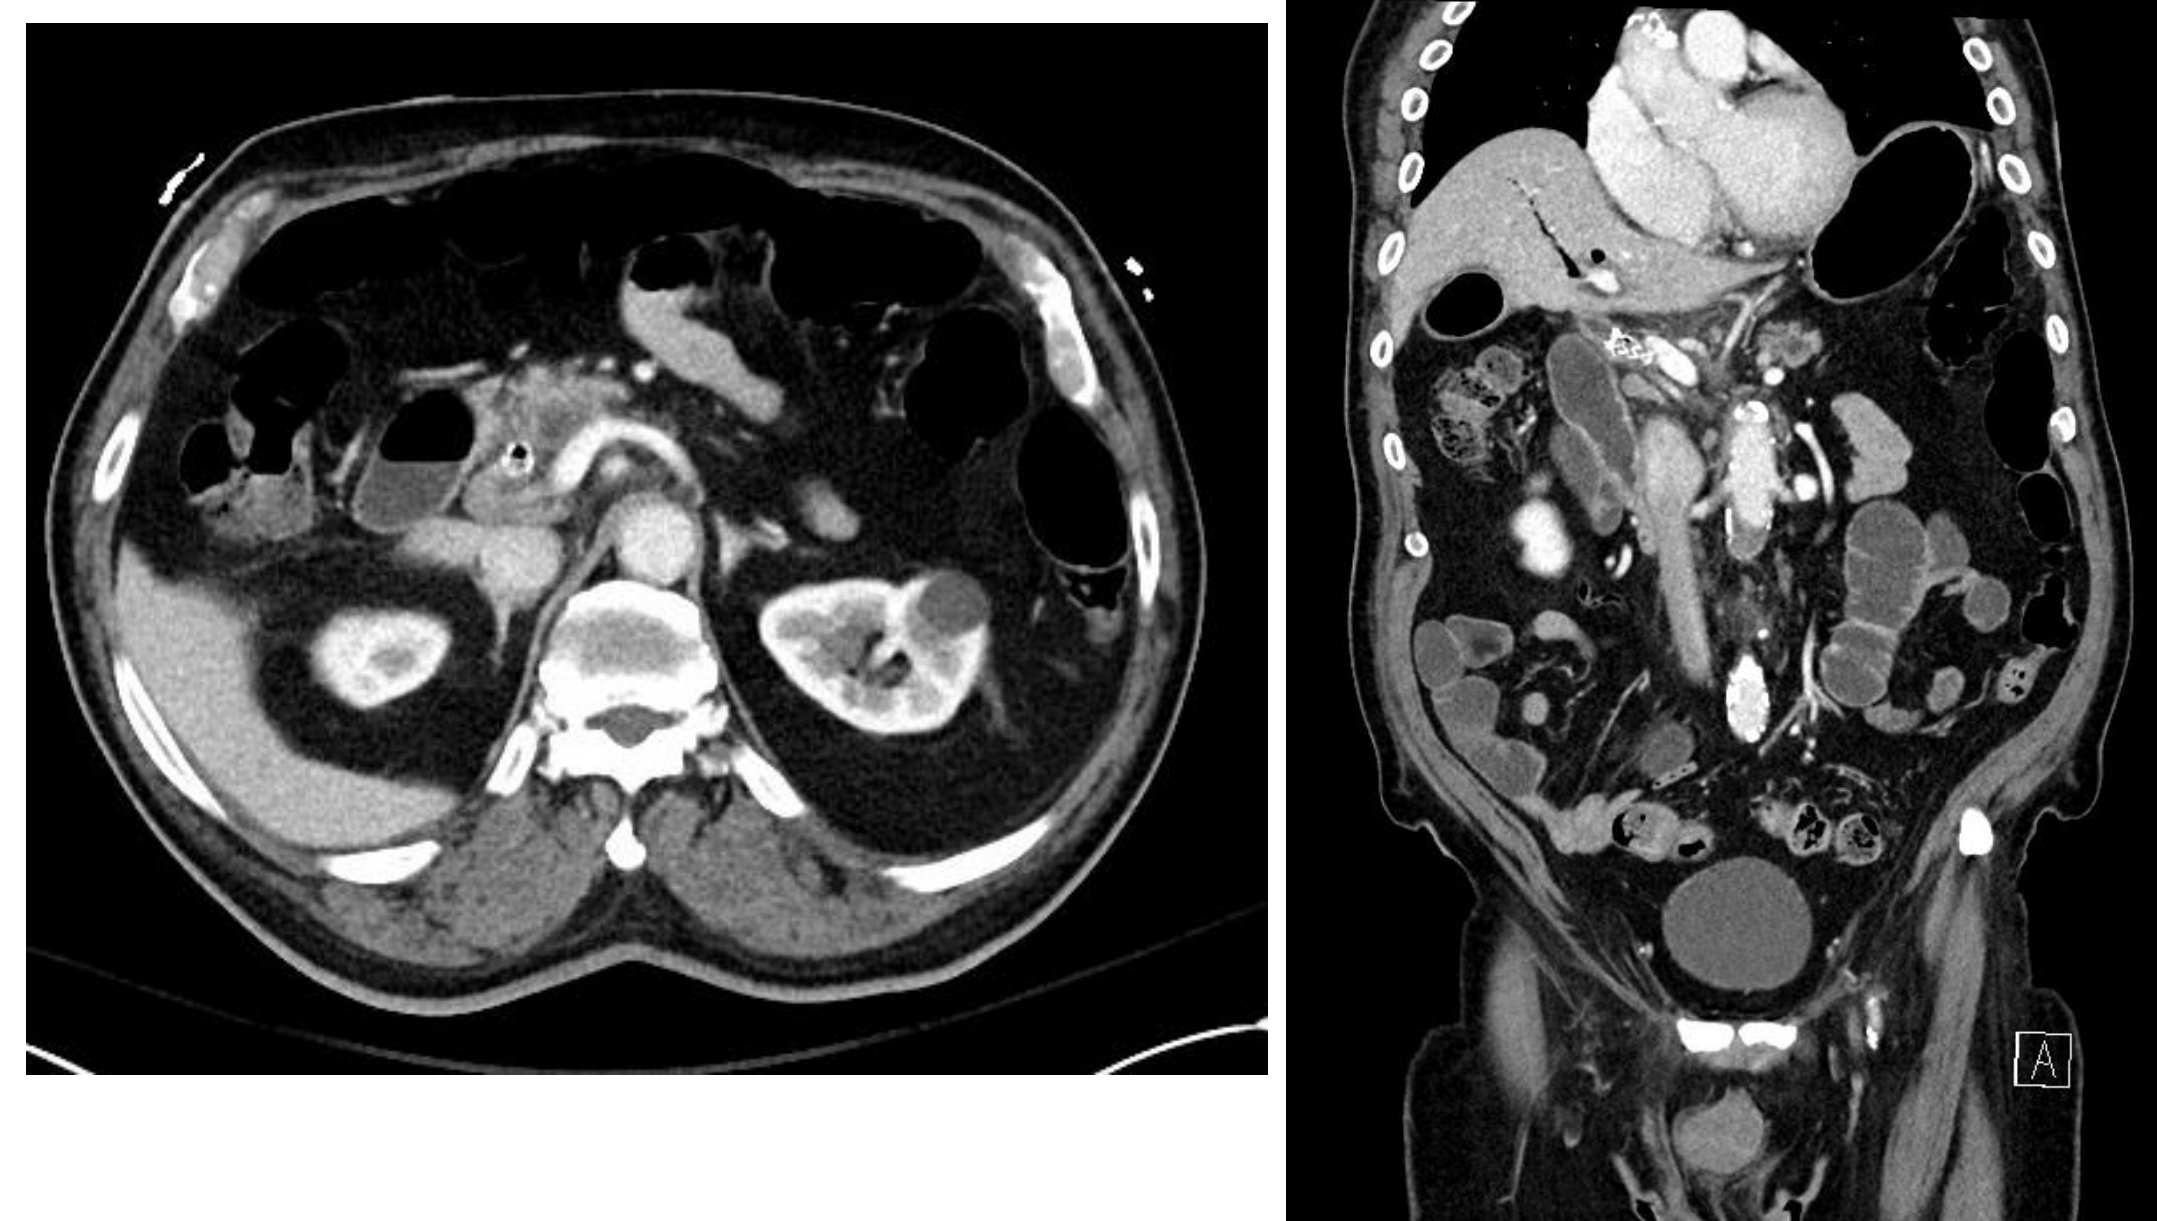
Axial (A) and coronal (B) CT images demonstrating a pericaval lymph node adjacent to the common bile duct stent, highlighting its anatomic relationship to the biliary system.
